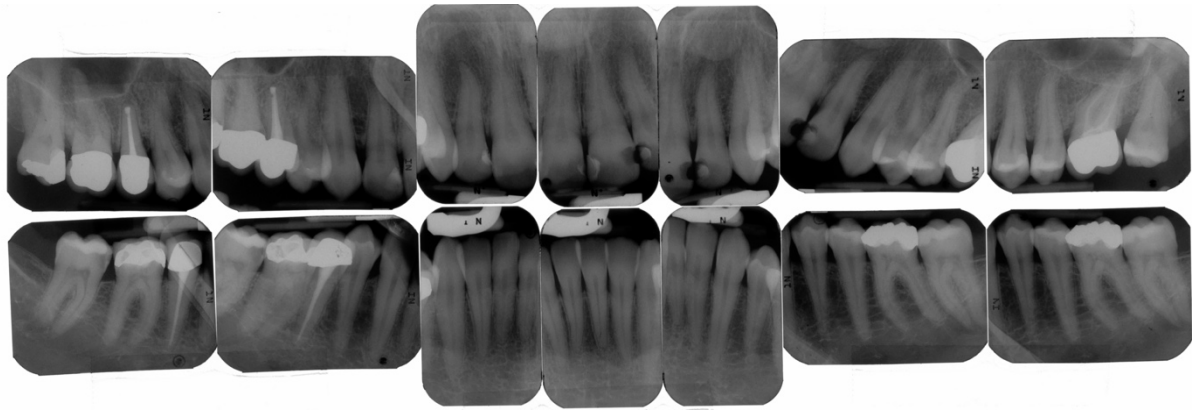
Periapical intraoral radiographs.
